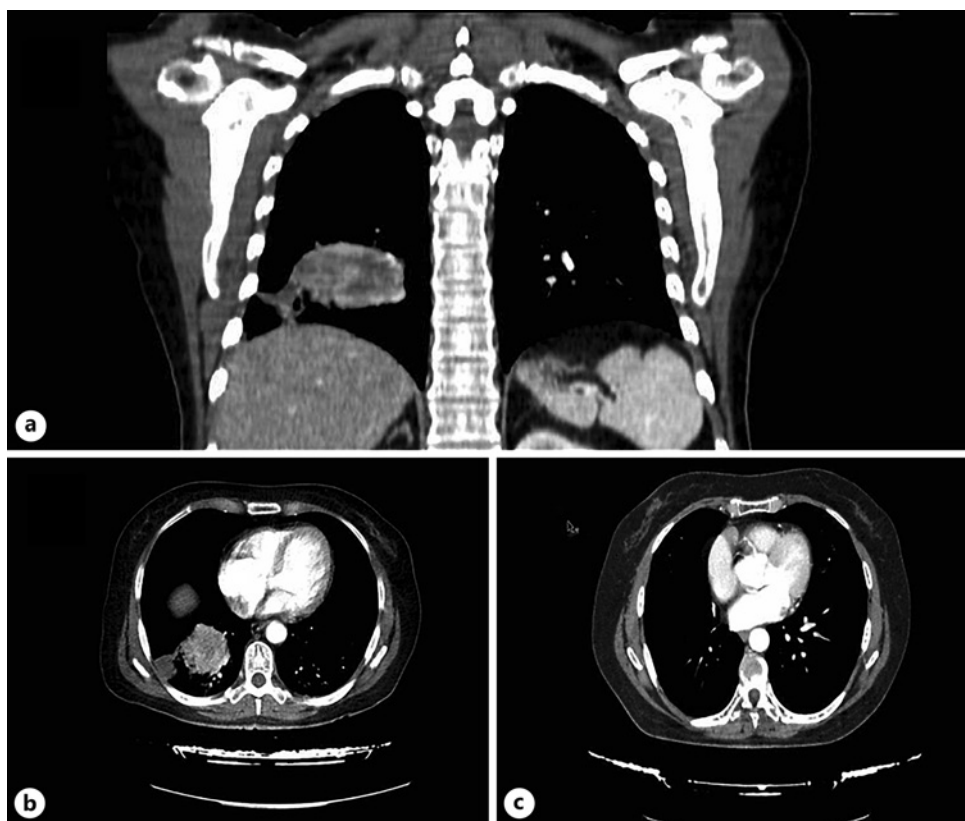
Evolution of the lung metastasis. a, b January 2018, image of mass approximately 56 mm in maximum diameter, located in the right lower lobe. c August 2019, control CT scan after lobectomy.
